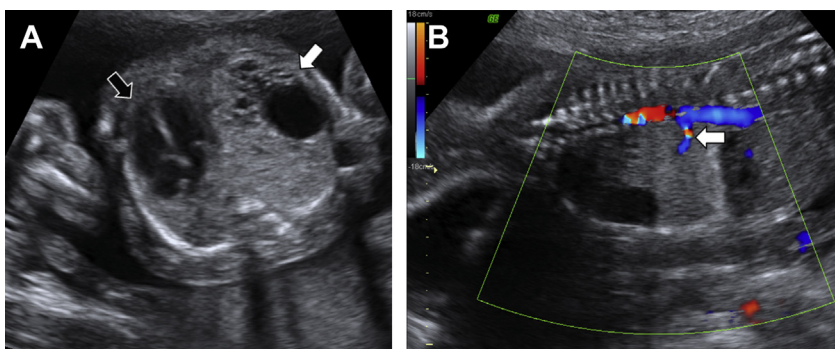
A 22-week-old fetus with congenital pulmonary airway malformation (CPAM) and bronchopulmonary sequestration (hybrid lesion). (A) Grayscale prenatal ultrasound shows a multicystic mass (white arrow) in the left lung displacing the heart (black arrow) to the right. (B) Color Doppler ultrasound image demonstrates a feeding systemic artery (arrow) arising from the aorta.
